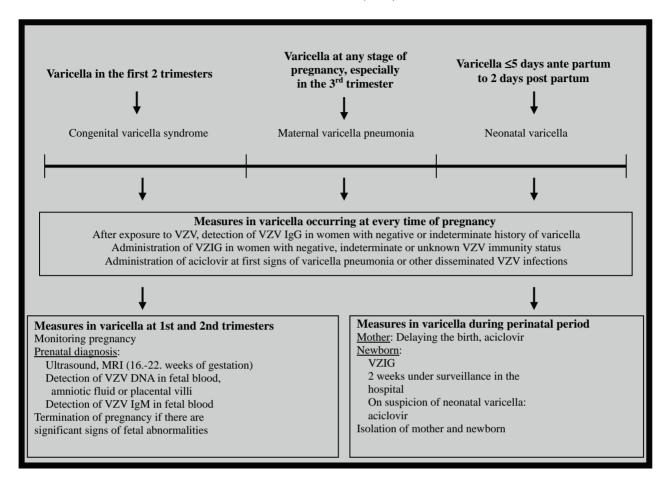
Measures in case of varicella during pregnancy depending on the point of time of infection; MRI: magnetic resonance imaging, VZIG: varicella-zoster immune globulin, VZV: varicella-zoster virus.
